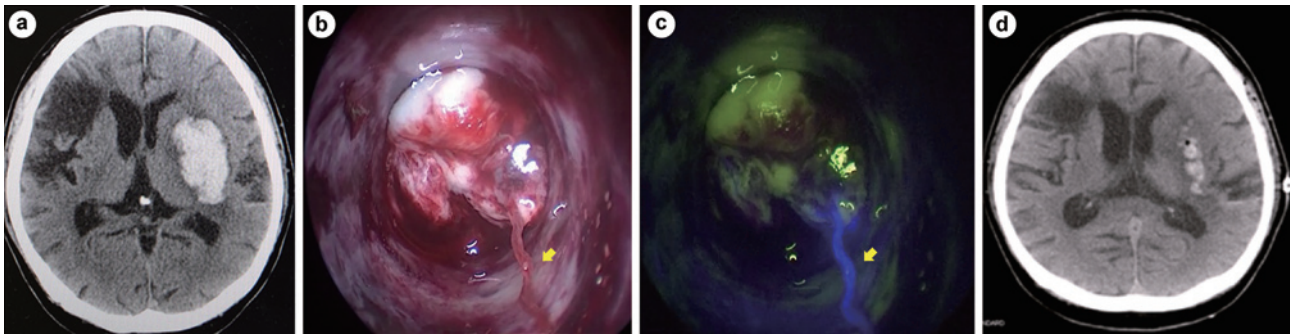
Case 1. a) CT image of the left putaminal hemorrhage, equivalent to 50 mL. b) Surgical view under the white light. c) Surgical view under the ICG mode. The arrowhead shows the disrupted perforating branch. d) Postoperative CT confirms the hemorrhage removal.
